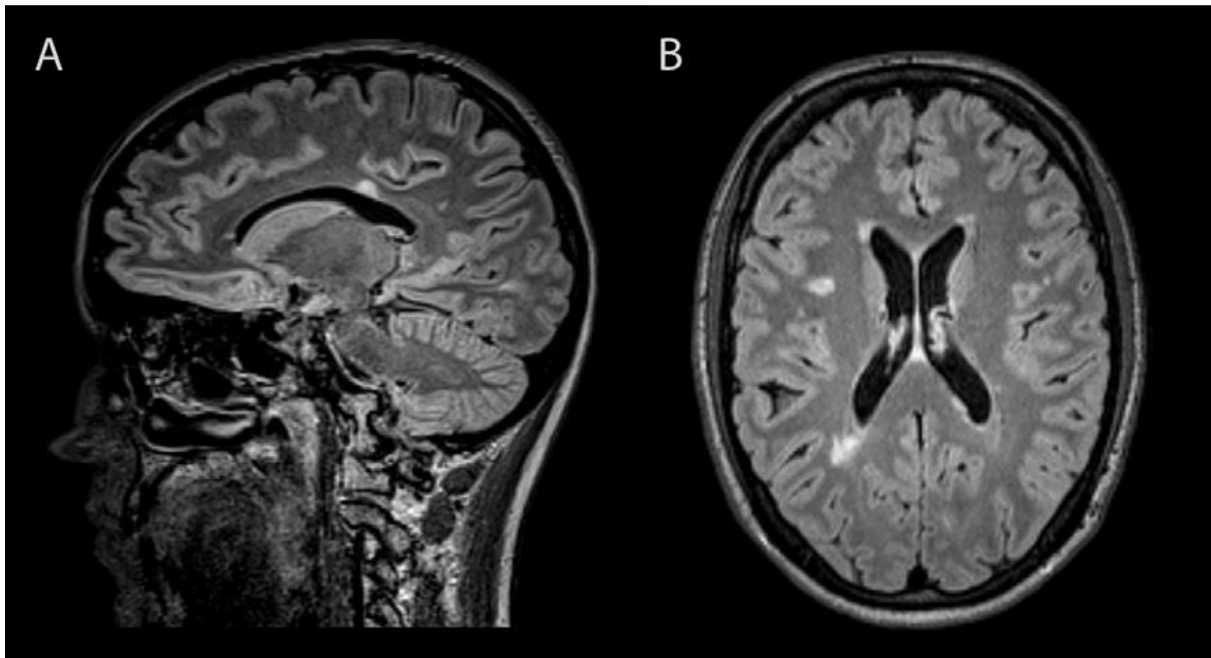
Overlapping demyelinating syndrome in two patients with NMDAR encephalitis. (A) FLAIR-hyperintense lesions in the corpus callosum of a 20-year-old female patient with NMDAR encephalitis, one lesion with a “Dawson finger” aspect typical for multiple sclerosis. Further demyelinating lesions were observed in the periventricular white matter with two of the lesions showing contrast- enhancement. Lesions were detected on a routine follow-up MRI, however the patient had suffered from fatigue during the last six months before MRI. Shortly after MRI, she developed hypoesthesia of both lower legs and bladder dysfunction. A treatment with IV steroids was initiated and symptoms partially remitted. (B) FLAIR hyperintense lesions in the periventricular white matter of a 26-year old female patient with NMDAR encephalitis. In total, 14 supratentorial lesions were detected and two lesions showed contrast enhancement. MRI was performed because the patient had reported intermittent double vision. The patient was treated with IV steroids and double vision remitted.
